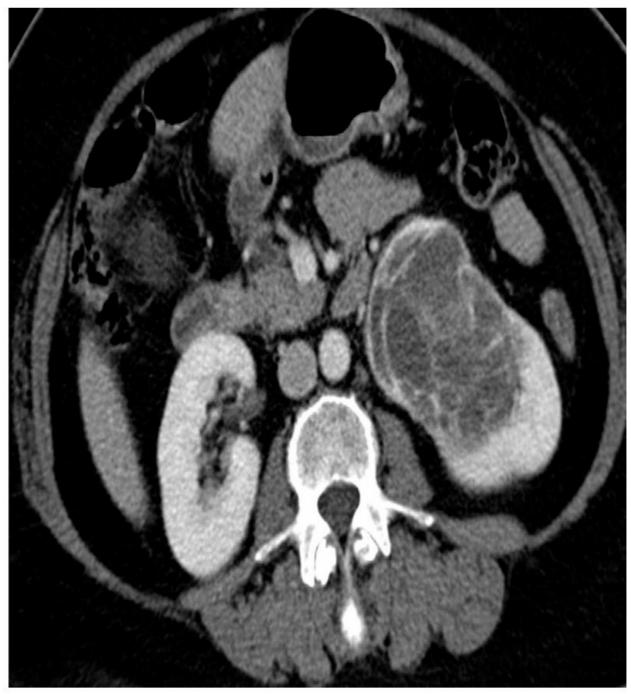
Multilocular cystic nephroma. Axial postcontrast computed tomography image showing a well-circumscribed multilocular cystic mass with septal enhancement. This lesion is indistinguishable from renal cell carcinoma on imaging.
